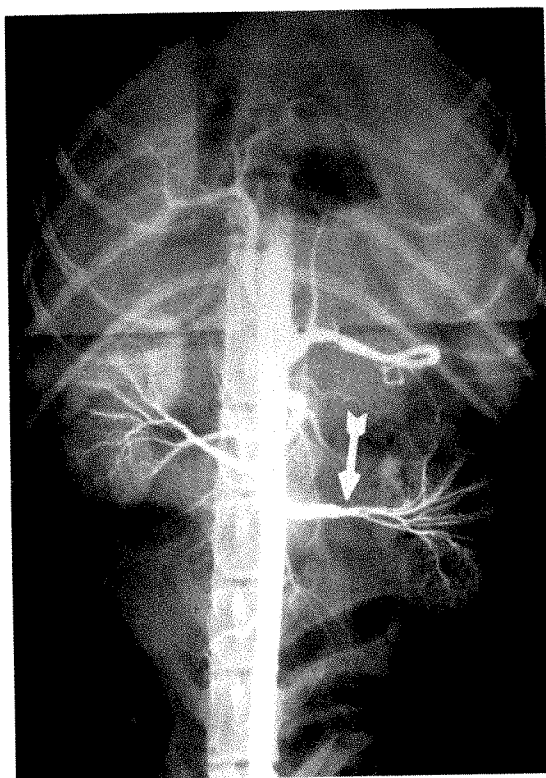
Case vi. The left renal artery was isolated and subjected to crushing by application of a hemostat several times. The segment became discolored and appeared contused. Roentgenogram following trauma shows irregular narrowed areas.
